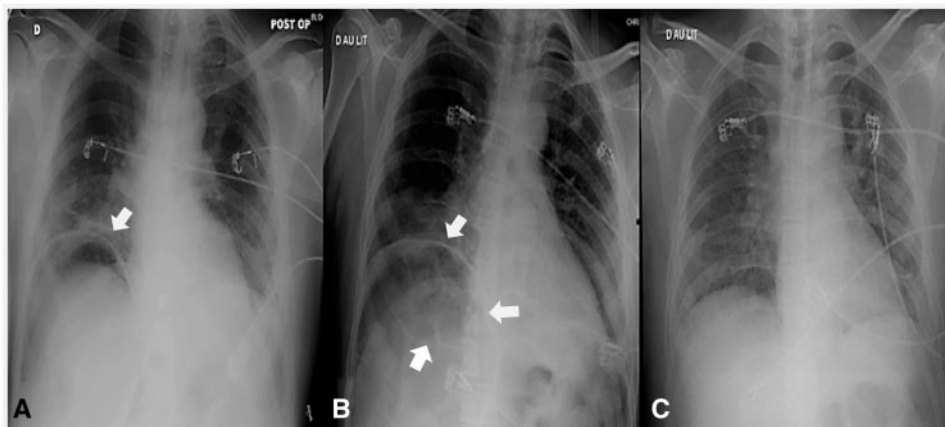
Chest radiographs. (A) Postoperative. White arrows indicate a pneumoperitoneum. (B) Preoperative. White arrows indicate Chilaiditi's sign. (C) After 24 h of high flow oxygen therapy.
